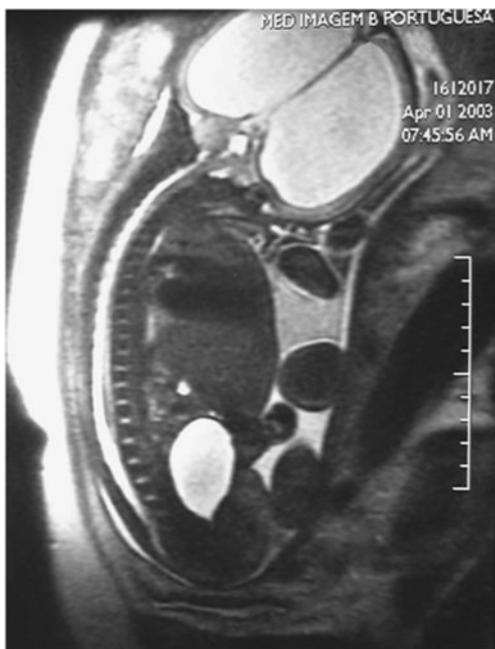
Fetal MRI at 32 weeks of gestation showing huge hydrocephalus due to aqueduct stenosis by Adams Bricker syndrome (X-linked hydrocephalus—a family linkage)
